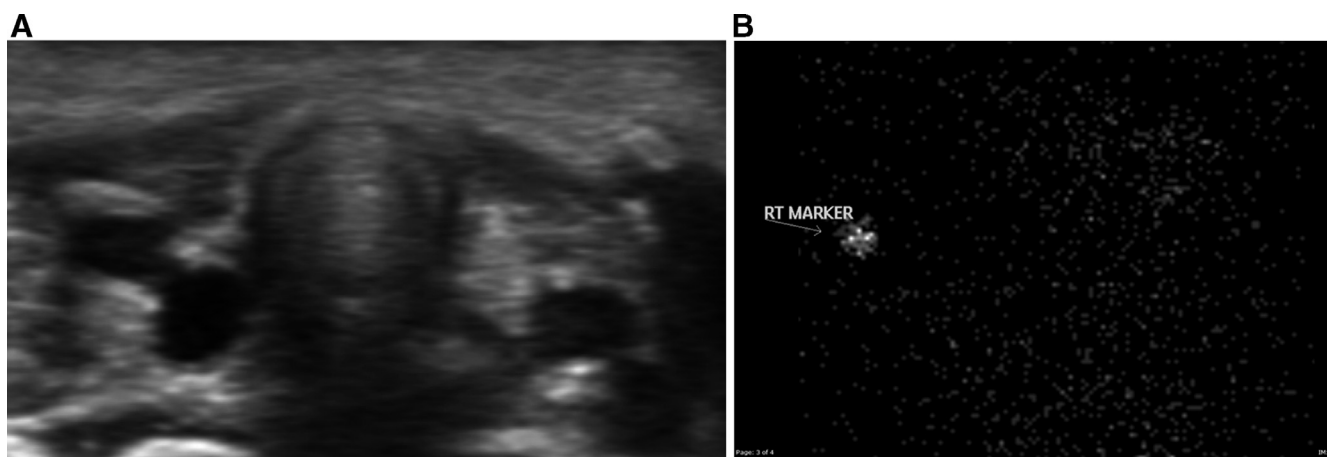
Thyroid agenesis. Eight-day-old girl with abnormal congenital blood spot screening. A. Transverse gray scale ultrasound image of the anterior neck along the thyroid bed shows no thyroid tissue. B. Iodine 123 scintigraphy performed 5 days later. Frontal projection shows no thyroid uptake.
